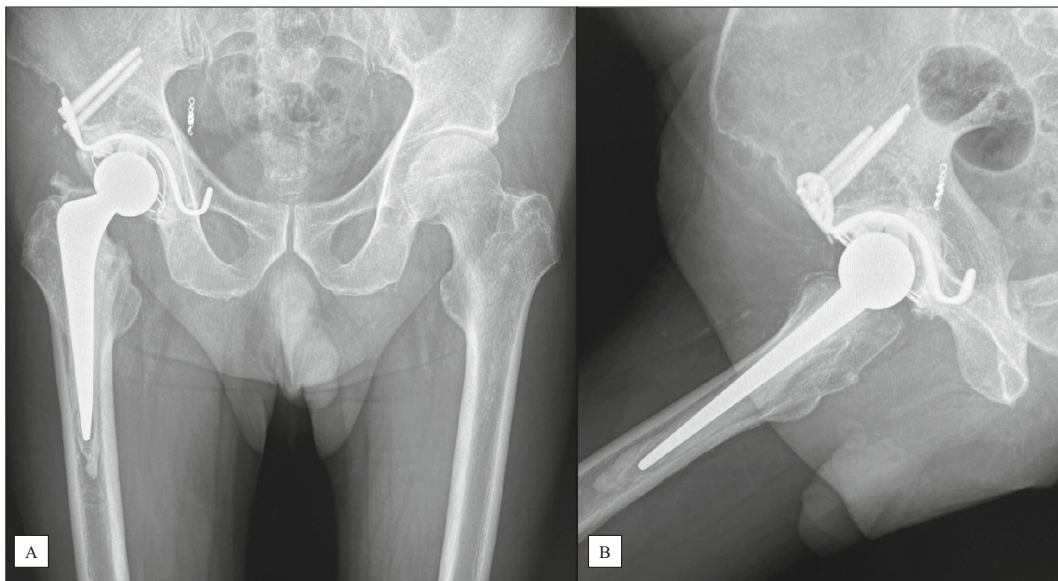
(A) Anteroposterior and (B) Lowenstein lateral postoperative radiographs of the hip joint demonstrated stable components without aseptic loosening at 14 months postoperatively.
